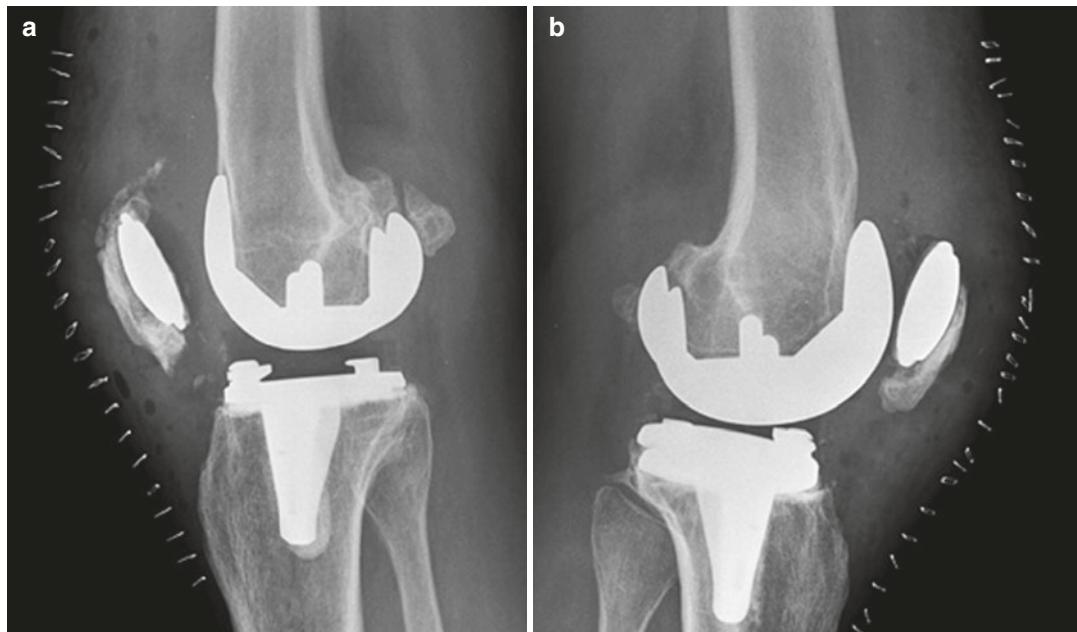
(a) Lateral immediate postoperative radiograph of the right knee demonstrates bony coverage over nearly the entire surface of the Trabecular Metal (TM) patellar component. (b) Lateral immediate postoperative
